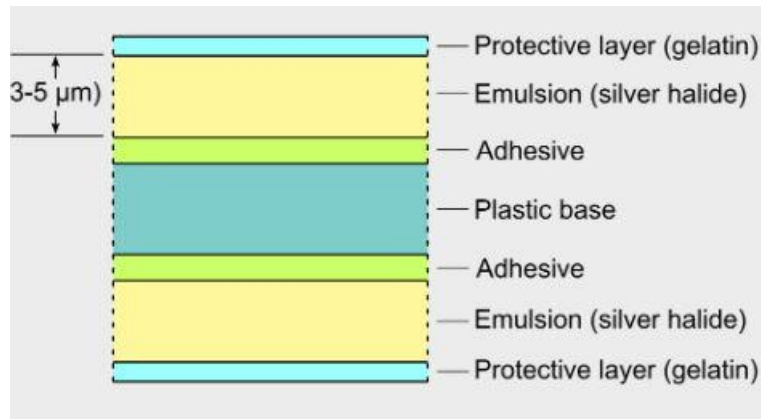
Structure of radiographic film dosimeter
